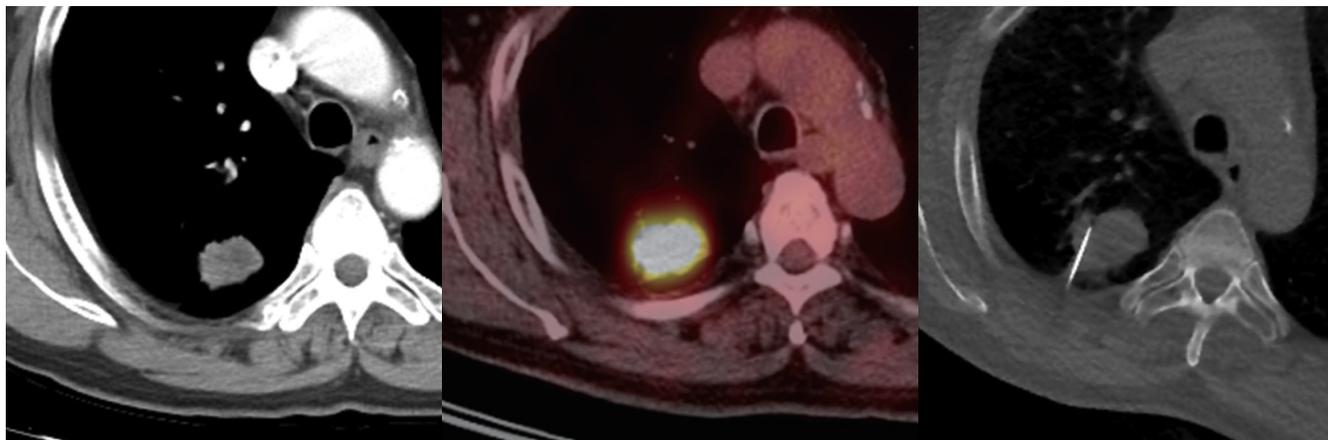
A 62-year-old male with a mass located at the right upper lobe posterior segment. PET/CT scan shows homogeneous uptake (SUVmax of 14.3), with no definite additional benefit before percutaneous transthoracic needle aspiration biopsy. Pathologic results revealed squamous cell carcinoma.
